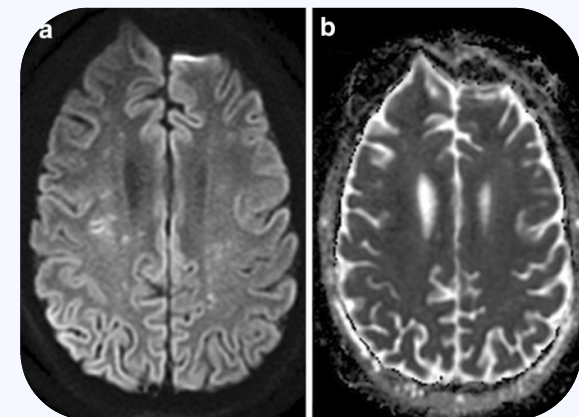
Consecutive axial diffusion-weighted magnetic resonance imaging (A) caudal to (B) cranial. Note the many punctate hyperintense foci in the bilateral cerebral hemispheres. These areas showed low signal on susceptibility-weighted sequences, indicating multiple microhemorrhages, a pattern consistent with fat embolism syndrome.
